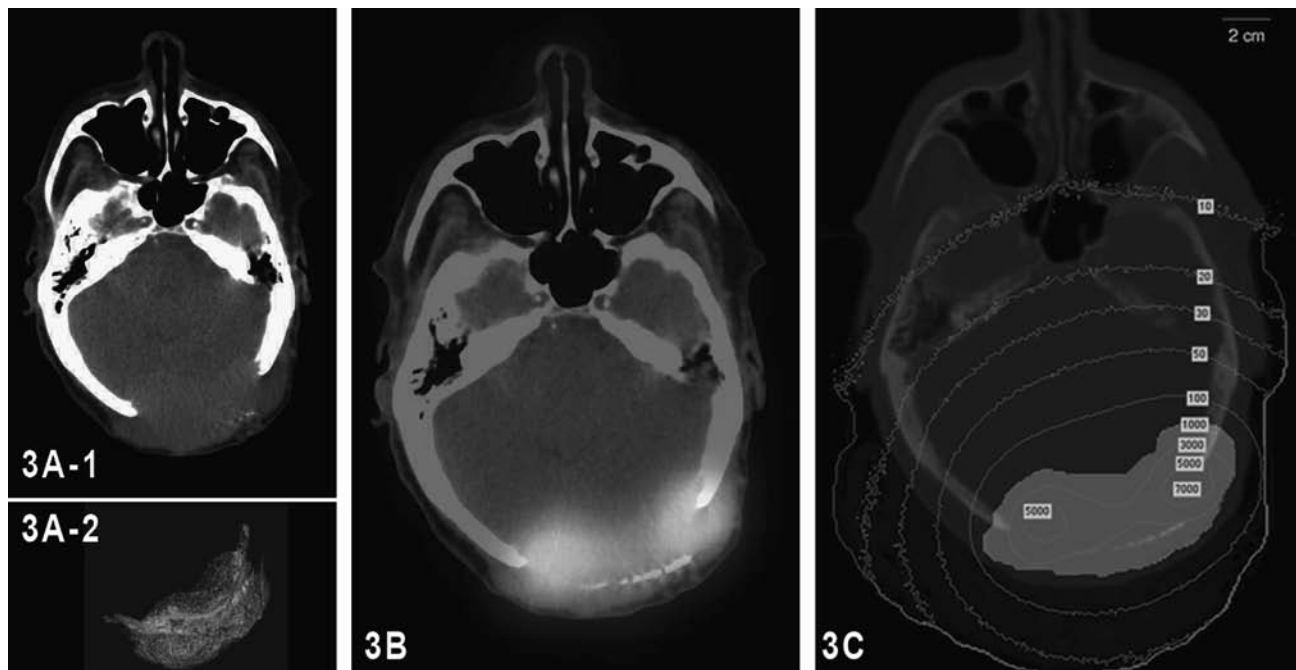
Images in July 2007 1 day before ^{131}I treatment. TSH 75 mU/L. CT transaxial images of the head were obtained at a different inclination from the MRI images in Fig. 2, but both CT and MRI portray tumor at maximum dimensions. (A1) 1, CT image and (A2) tumor with volume of 219 mL. (B) Single photon emission tomography fused with CT (SPECT-CT) demonstrating radioactivity concentration in tumor. (C) CT with superimposed iso-dose levels of cGy in the tumor (shaded) and brain. The absorbed dose to the brain is from gamma (photon radiation) emanating from the tumor. Mean radiation dose to the tumor was 1970 cGy. Color image available online at www.liebertonline.com/thy.
